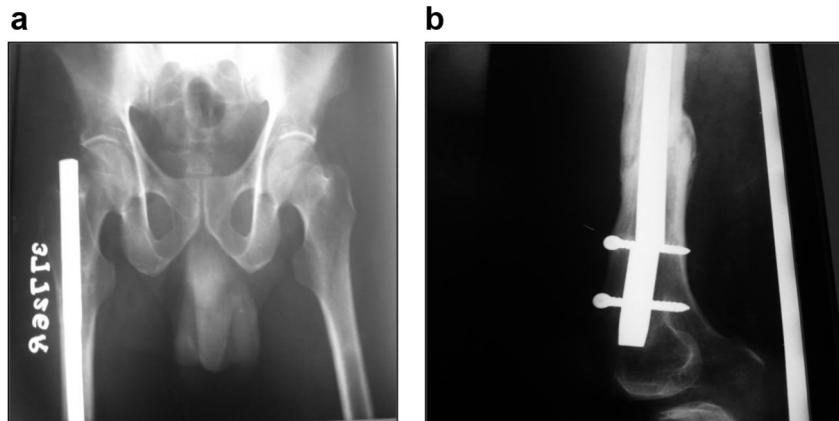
(a) and (b): X-ray of patient showing broken intramedullary cannulated nail broken at distal screw site.
